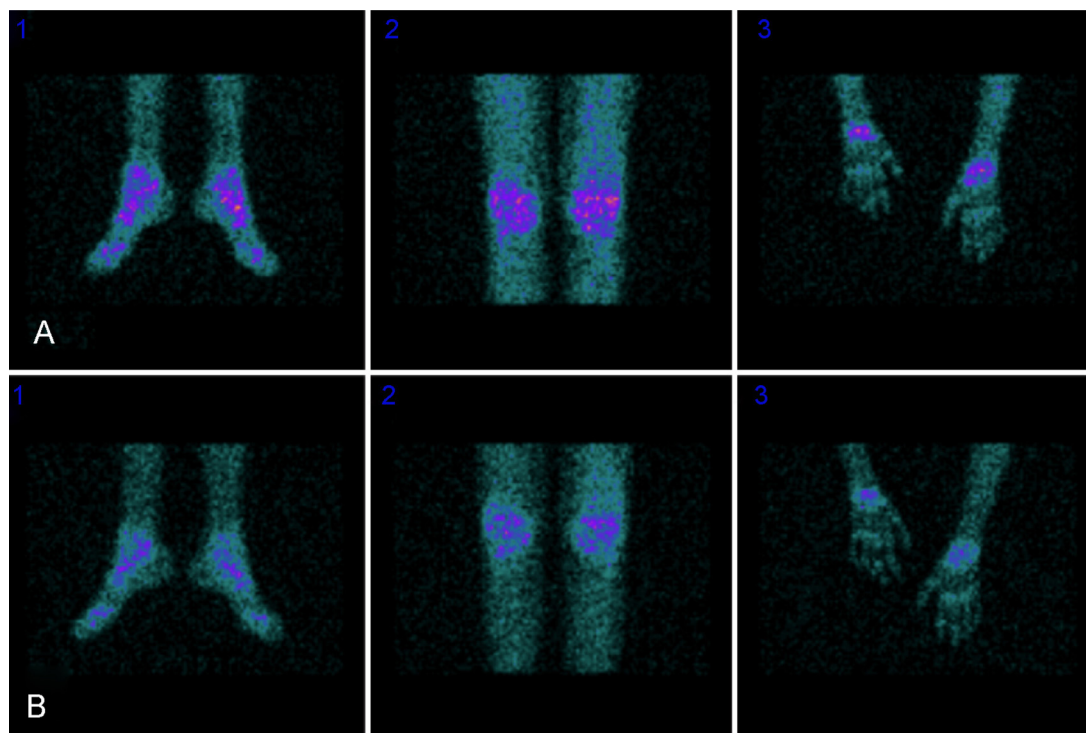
99mTc-OKT3 scintigraphy images before (A) and after (B) the use of anti-TNF-inhibitor, demonstrating ankles, knees and wrists uptake.
